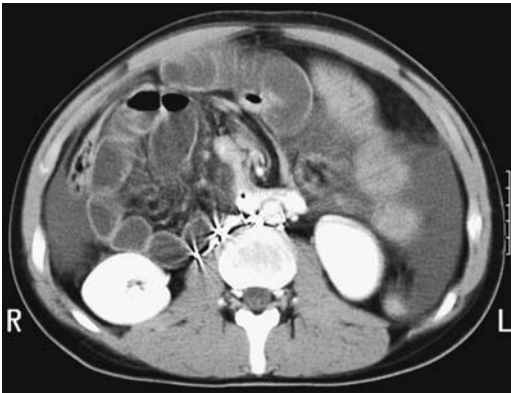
Small bowel obstruction in a paraduodenal hernia in a man who had previous testicular carcinoma resection and retroperitoneal lymph node dissection. Contrast-enhanced CT reveals dilated small bowel loops posterior to the duodenum. Involved bowel wall is thickened and enhances considerably. Surgery found a strangulated paraduodenal hernia. (Courtesy of Patrick Fultz, M.D., University of Rochester.)
